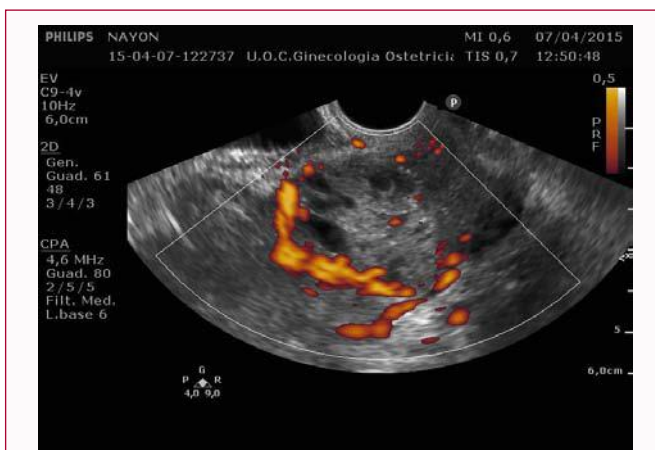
Vaginal ultrasound showed an isthmic, vacuolated, in homogeneous echogenic mass very vascularised.
